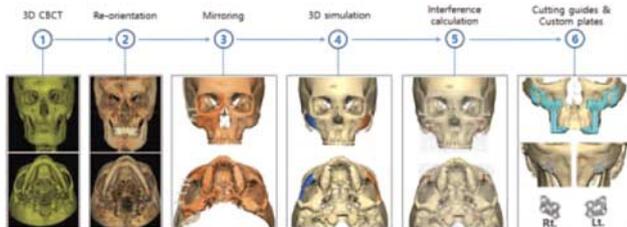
Work-flow of reduction malarplasty aided by 3D virtual surgery, CAD/CAM, and 3D printing technologies. Before surgery, 3D facial CBCT was taken, and reorientated according to patient's natural head position. Virtual skull image was produced and 3D asymmetry was measured by mirroring for determining surgical plan. By moving the malar segment to desired position, interference can be calculated. At final position of the malar segment was confirmed, cutting guides and customized titanium plates were designed and manufactured by CAD/CAM and 3D printing technologies. 3D, three-dimensional.
